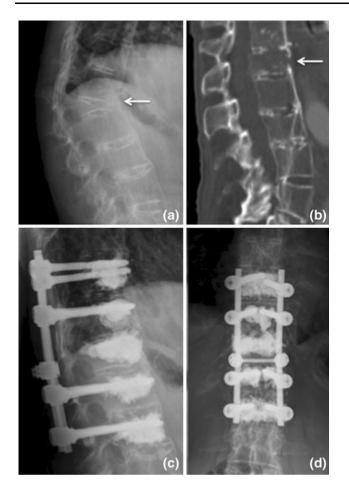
A 72-year-old male patient with M. Bechterew and an unstable type B fracture of the ankylosed spine at T11/12. a Standing radiographs shows a relevant collapse of T12 that results in a large ventral defect after alignment in the supine position for the CT scan (b). The fracture was treated with cement-augmented stabilisation and filling of the anterior defect with PMMA (c, d)
